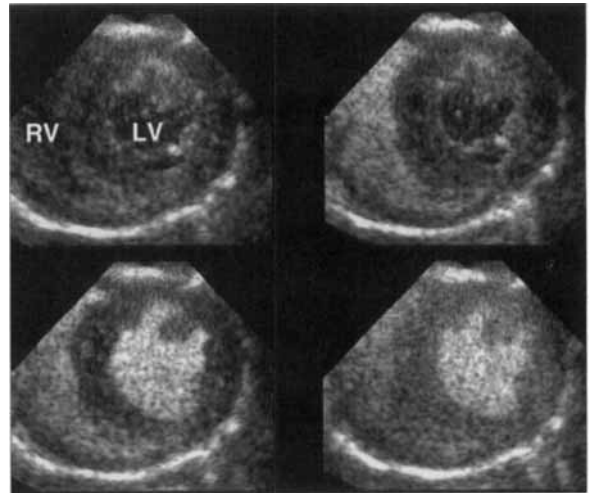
Two-dimensional echocardiographic images collected by intermittent harmonic imaging in ultrasound mode and corresponding to baseline conditions (left top), right ventricular (RV) cavity enhancement (right top), left ventricular (LV) cavity enhancement (left bottom) and myocardial contrast enhancement (right bottom). RV = right ventricle; LV = left ventricle.
